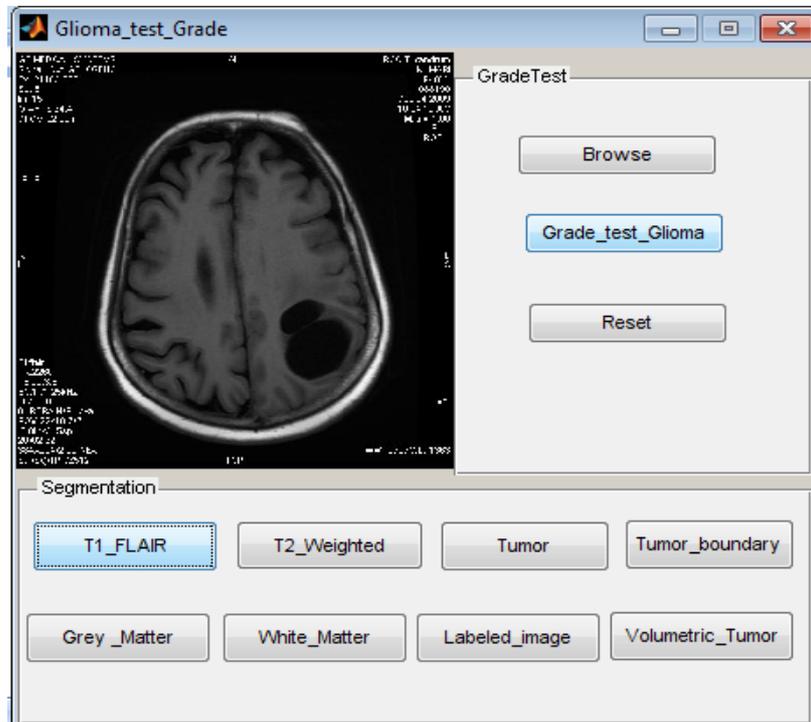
T1 FLAIR image when the push button T1_FLAIR is enabled. This is for selecting one of the input image for segmentation
